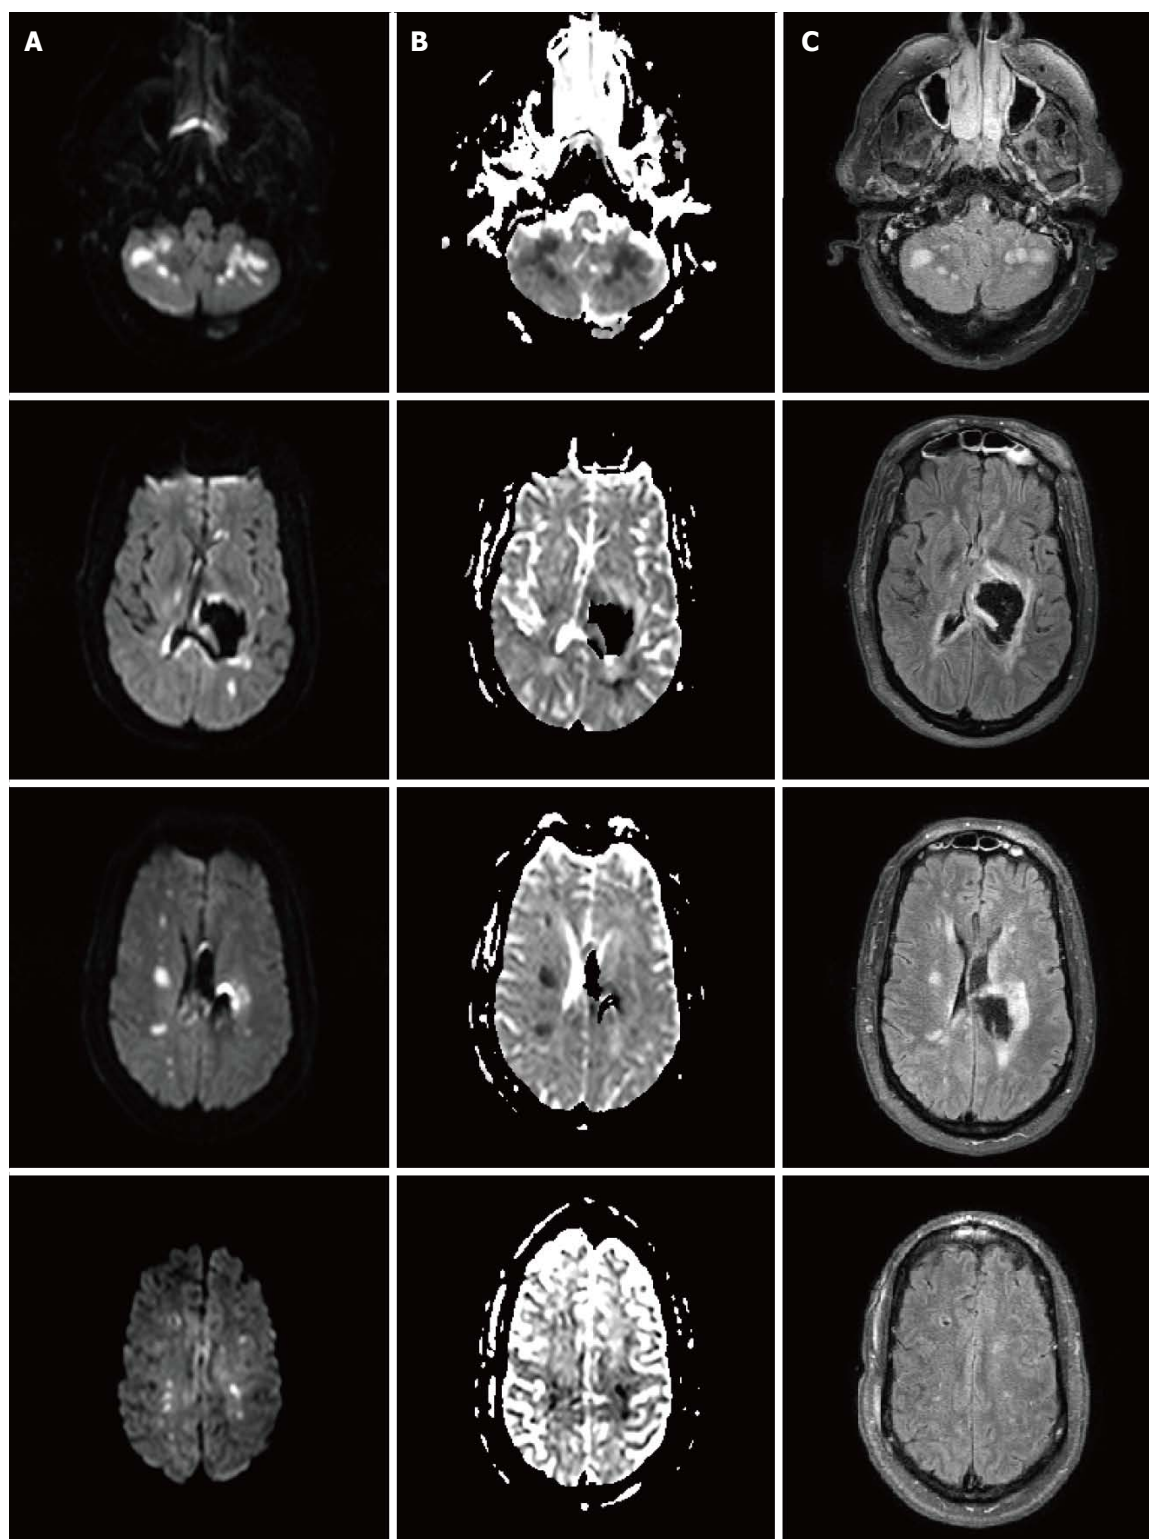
Brain magnetic resonance imaging with diffusion weighted imaging (A), apparent diffusion coefficient (B) and FLAIR sequences (C) showing multiple areas of infarction in the internal border zone areas of bilateral cerebral and cerebellar hemispheres. There is no evidence of perihematoma infarction. MRI: Magnetic resonance imaging.
